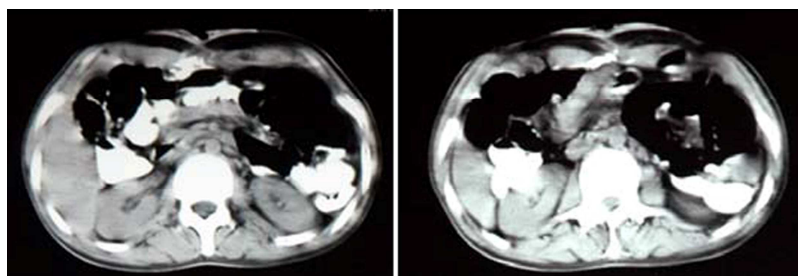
Abdominal CT scan demonstrating the intra-abdominal heterotopic ossification of the parietal peritoneum
